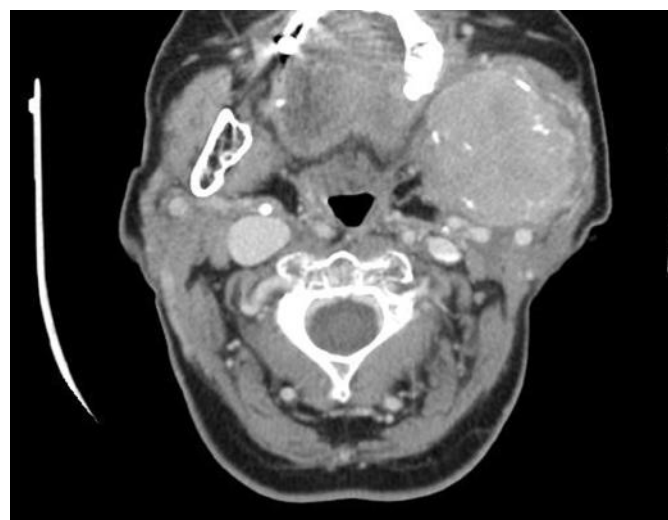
CT scan of the mandible shows a large osteolytic lesion of the left mandible infiltrating the surrounding soft tissues.
